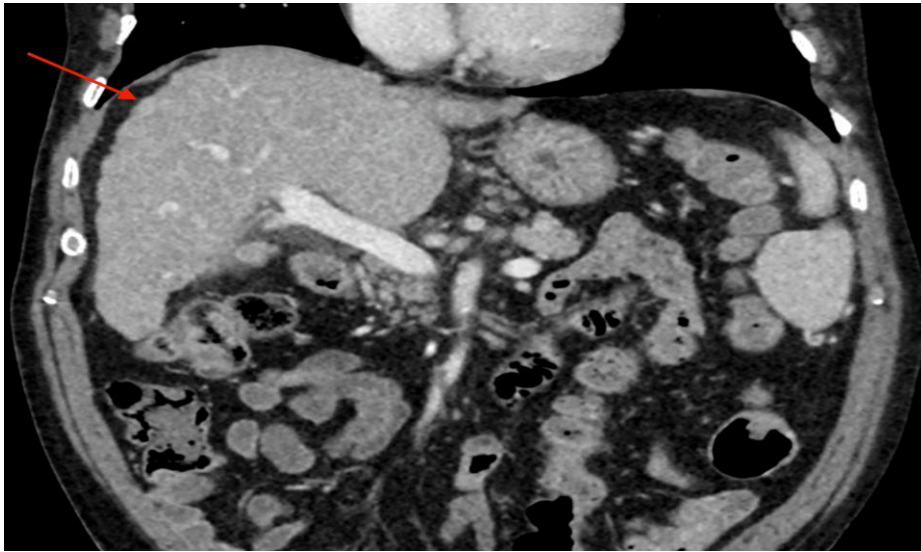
Coronal CT of the abdomen and pelvis with IV contrast
